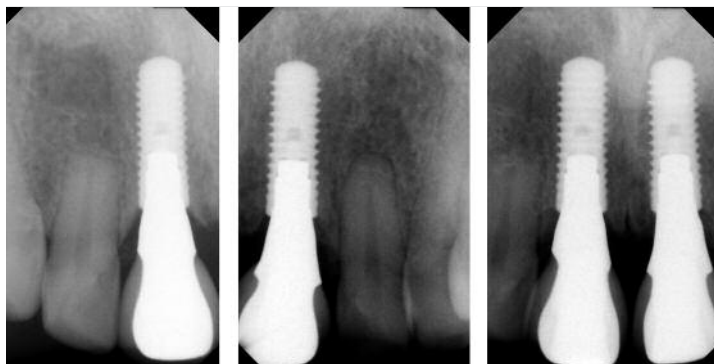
Radiograph 1 year post insertion of the restorations, note the preservation of the marginal bone level.
